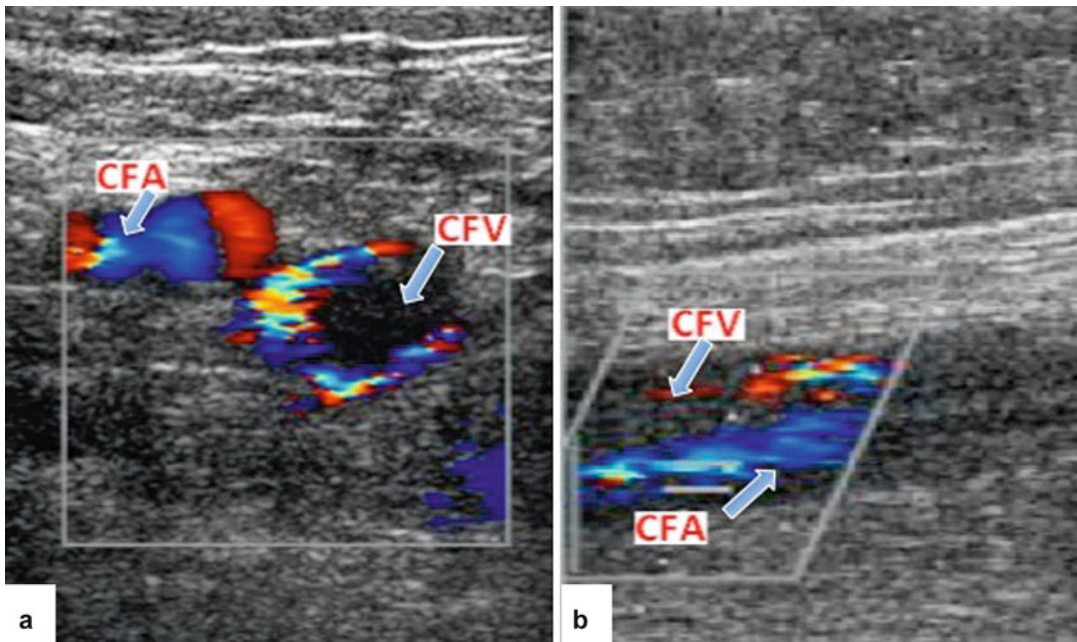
Transverse (a) and sagittal (b) images of the right lower extremity from color Doppler ultrasound demonstrating an acute common femoral vein (CFV) thrombosis and normal blood flow in the common femoral artery (CFA)
